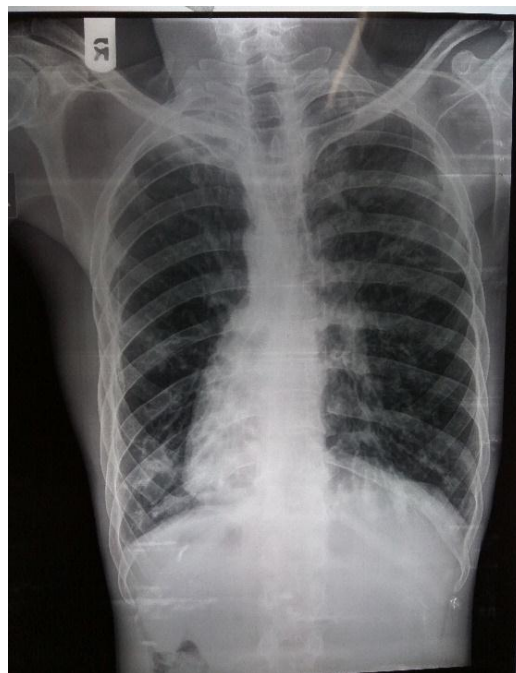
X-ray chest PA view
